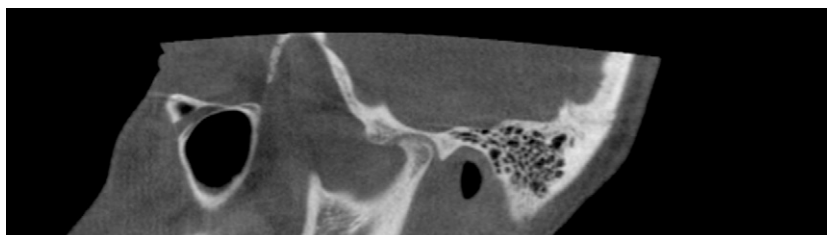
CBCT of juvenile osteoarthritis: deformed (remodelled) joint: osteophyte, sclerosis and cortical erosions (female, 13 years).
